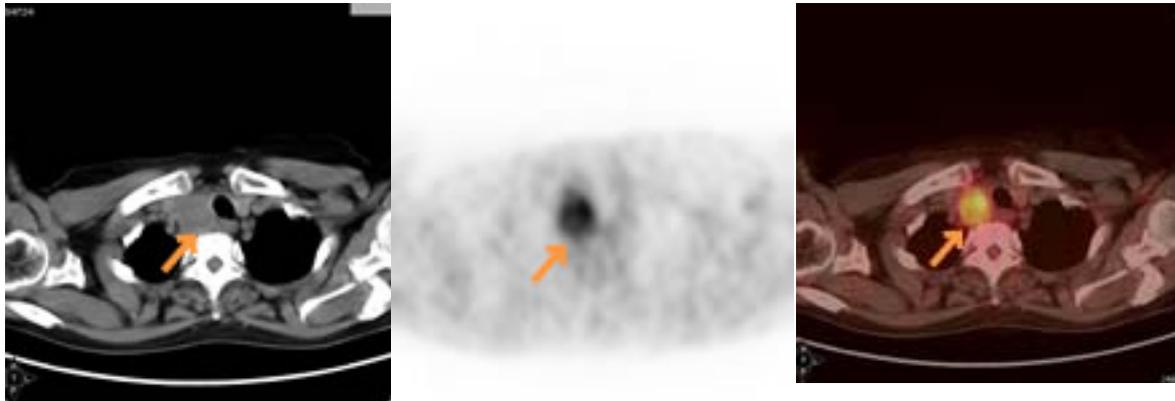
Example of image fusion at PET studies. Left: Detailed anatomy image from CT tomography. Centre: Image from PET study (no anatomy details present). Right: Image fusion of CT and PET images showing the tumour location into the detailed anatomy image.
